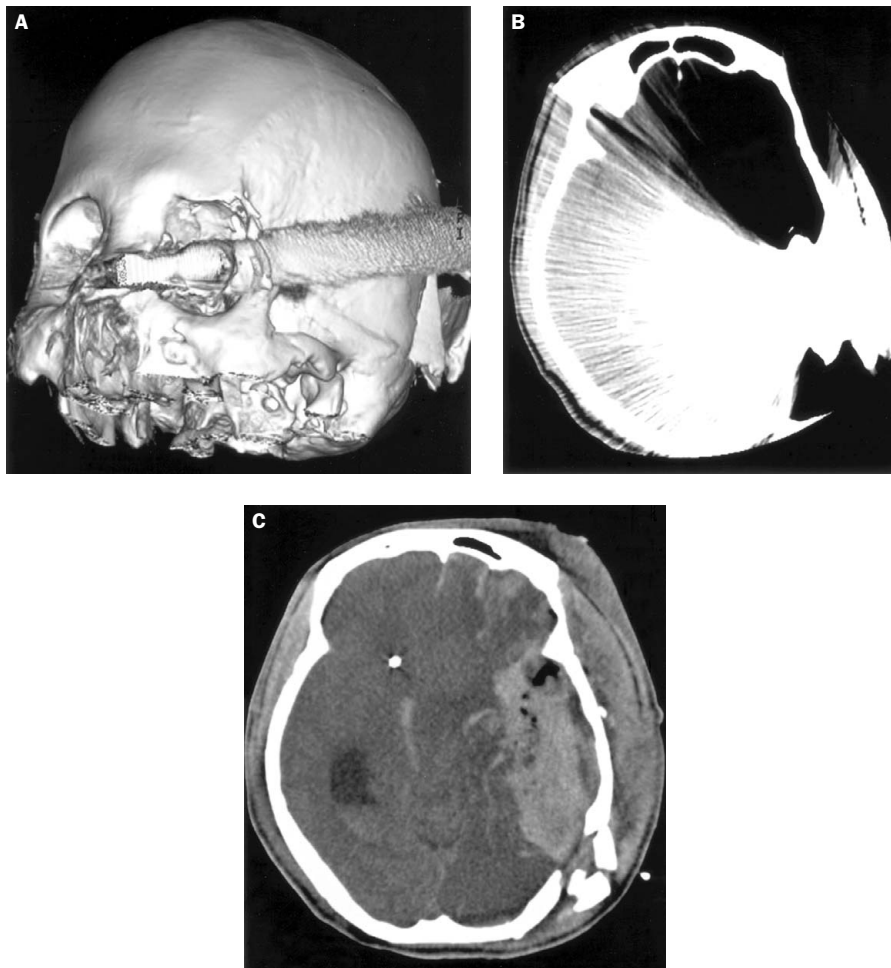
Case 2: (A) 3-dimensional reconstruction computed tomography (CT) shows that the metal bar has gone through the medial canthus of the left orbit and caused ipsilateral occipital bone fracture. (B) CT reveals marked artifacts along the trajectory of penetration and the basal cisterns could not be assessed. (C) Postoperatively, CT reveals large residual (or delayed) hematoma with severe brain shift.
